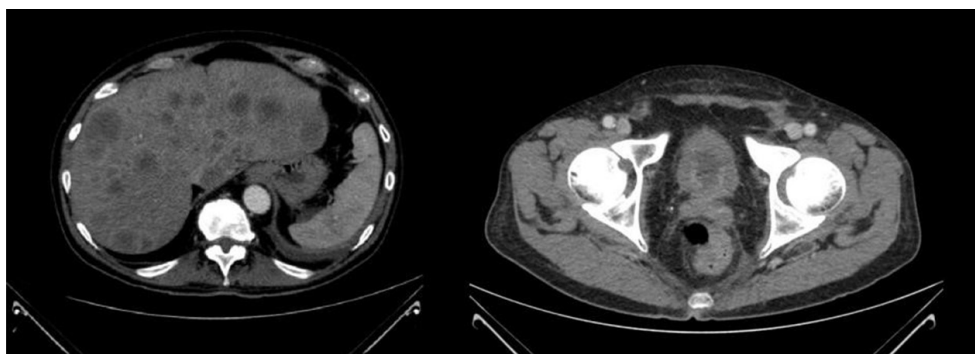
CT scan showing liver metastatization and rectal thickening
